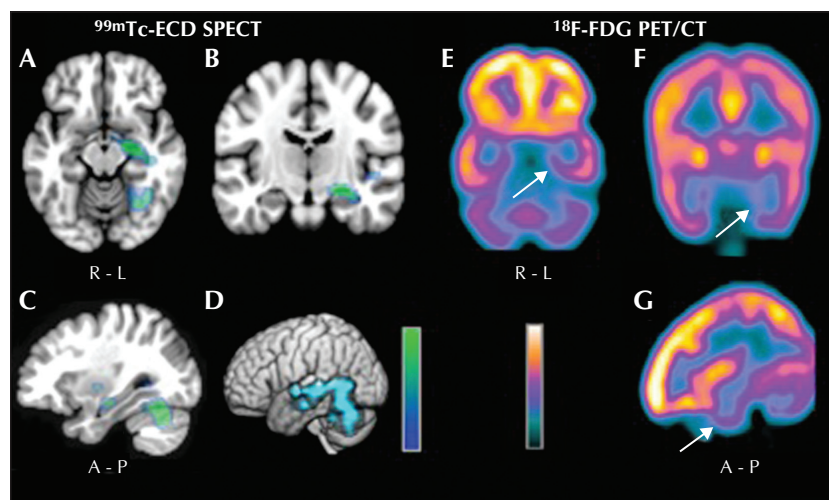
Interictal ^{99m}Tc -ECD SPECT and ^{18}F -FDG PET/CT of the brain. Statistical parametric mapping (SPM) of interictal SPECT showing reduced regional cerebral blood flow (rCBF; blue green colour scale) on the mesial and basal left temporal lobe and cerebellum, on transversal (A), coronal (B), and sagittal (C) slices, and 3D reconstruction (D). ^{18}F -FDG PET/CT shows glycolytic hypometabolism (white arrows) in the left temporal lobe, on transversal (E), coronal (F), and sagittal (G) slices.
